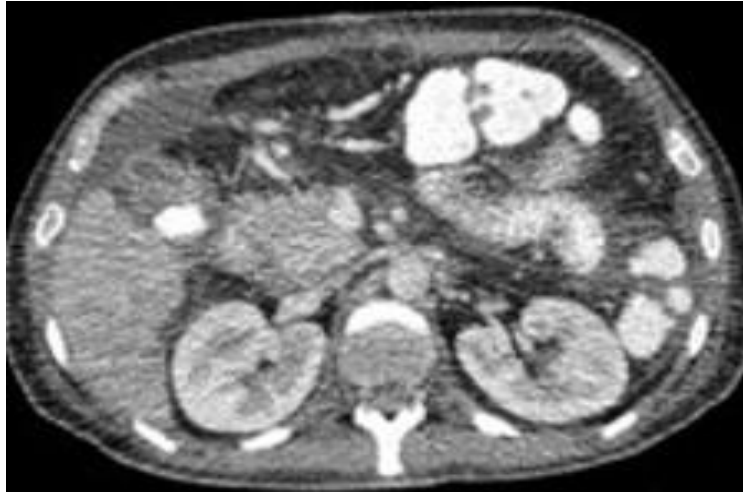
Biopsy of the bowel and splenectomy results revealed infection and bone marrow biopsy diagnosis was Myelodysplastic syndrome. The abdominal pathologic findings were disappeared at the third month follow up diagnostic CT.
